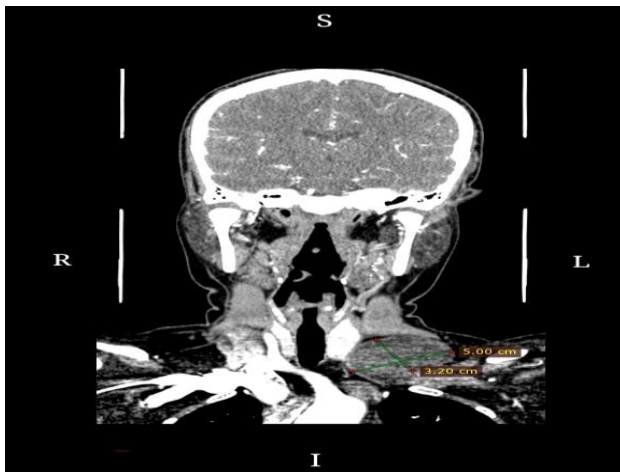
Coronal section of CTA head and neck showing cystic lesion over the left supraclavicular region.
